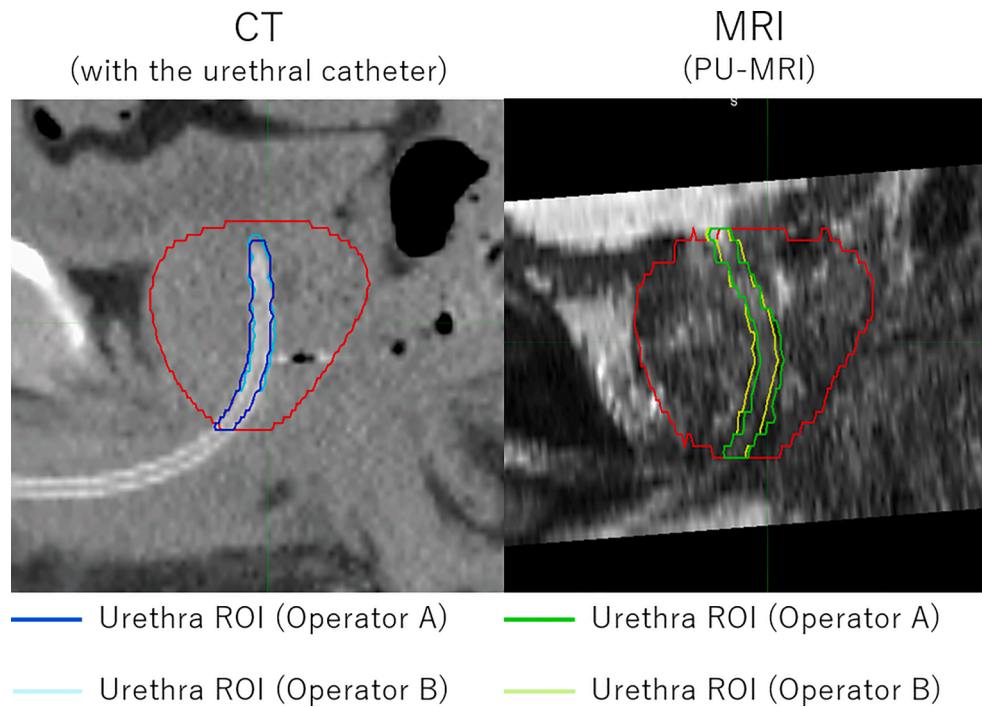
Contoured urethral ROI by two operators (Case 2). The urethral ROI was identified with a urethral catheter in CT and without a urethral catheter in PU-MRI. ROI: region of interest, CT: computed tomography, PU-MRI: post-urination magnetic resonance imaging.
